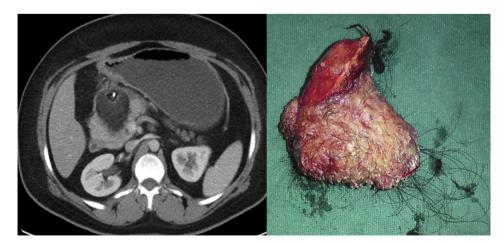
CT scan of abdomen (left panel) showing a well defined hypoattenuating mass in the head of pancreas with areas of calcification (Rokitansky protuberance). On gross pathological examination (right panel), cystic mass consisting tufts of hair, cartilagenous and bony tissues, consistent with a dermoid cyst.
